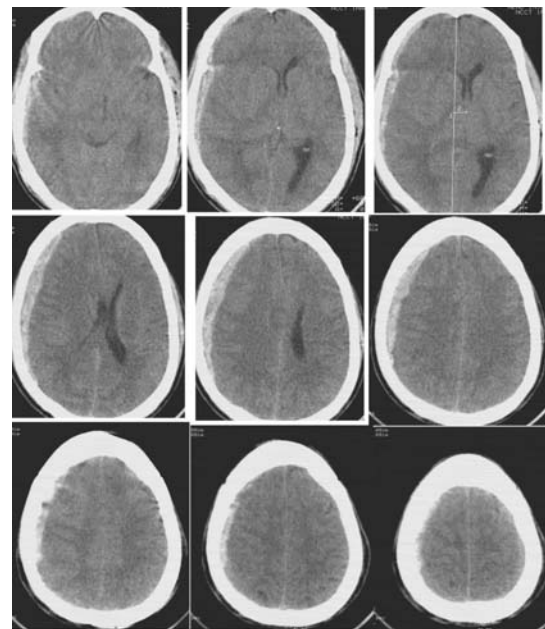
CT scan showing acute SDH in right frontotemporoparietal region. There is evidence of subarachnoid hemorrhage and midline shift of 6 mm
